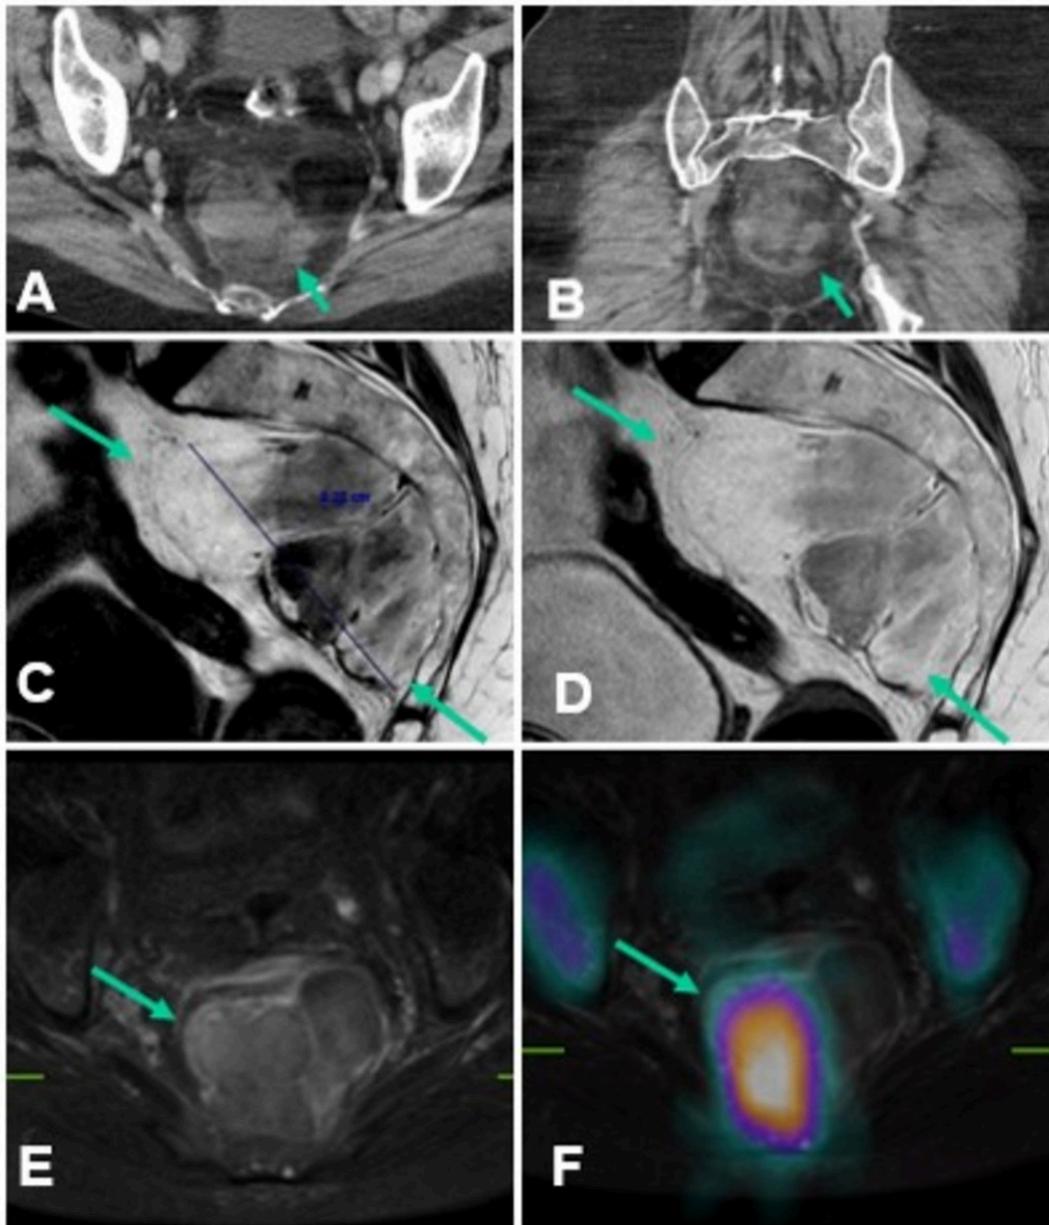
Presacral myelolipoma. (A, B) Axial and coronal contrast-enhanced CT image shows lobulated presacral mass (arrow) with mixed fatty and soft-tissue densities. (C,D) Sagittal T1 and T2-weighted MR images show high-signal-intensity encapsulated mass (arrow) in presacral region. There are internal regions of intermediate signal intensity within it. (E) Axial T1-weighted fat-saturated gadolinium-enhanced MR image shows mild enhancement of tissue (arrow) within presacral myelolipom. (F) Technetium-99m sulfur colloid scintigraphy fused image shows uptake (arrow) in soft-tissue density of presacral myelolipoma.
